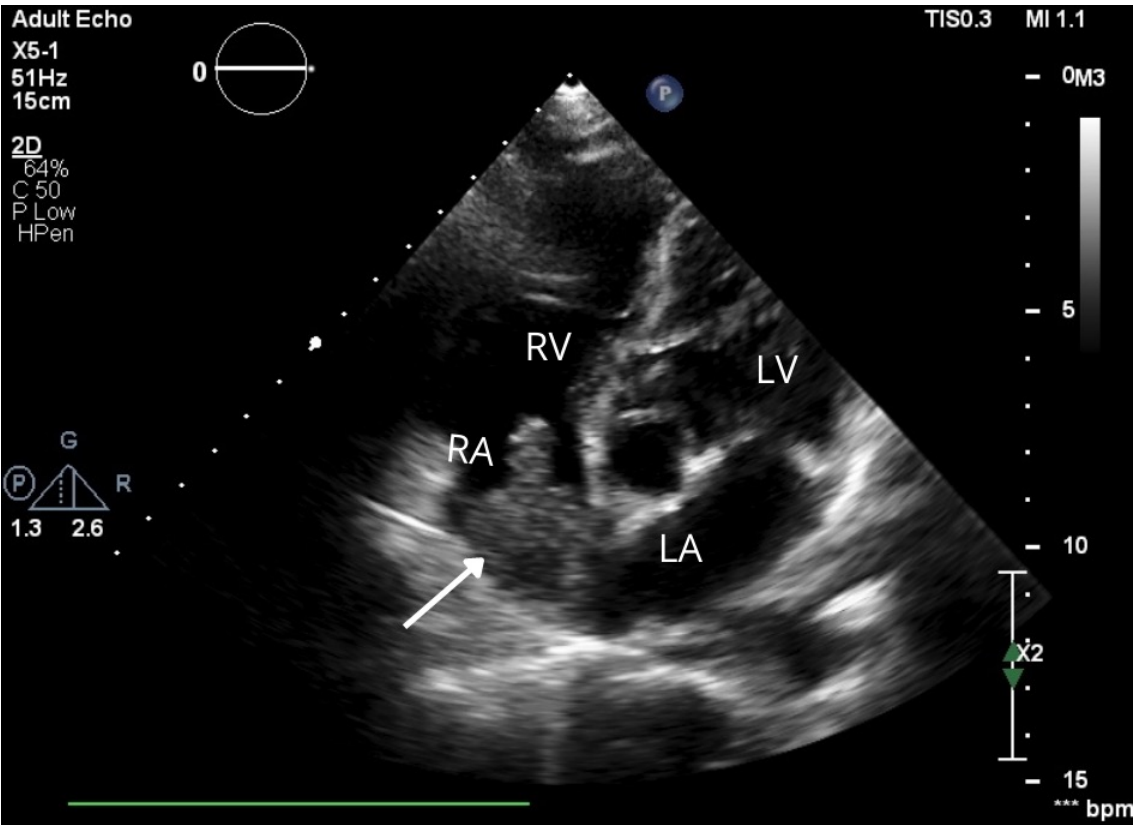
4- Chamber view on transthoracic echocardiography revealing the large mass measuring 3.05 x 3.56 cm occupying 80% of the right atrium. (white arrow)
